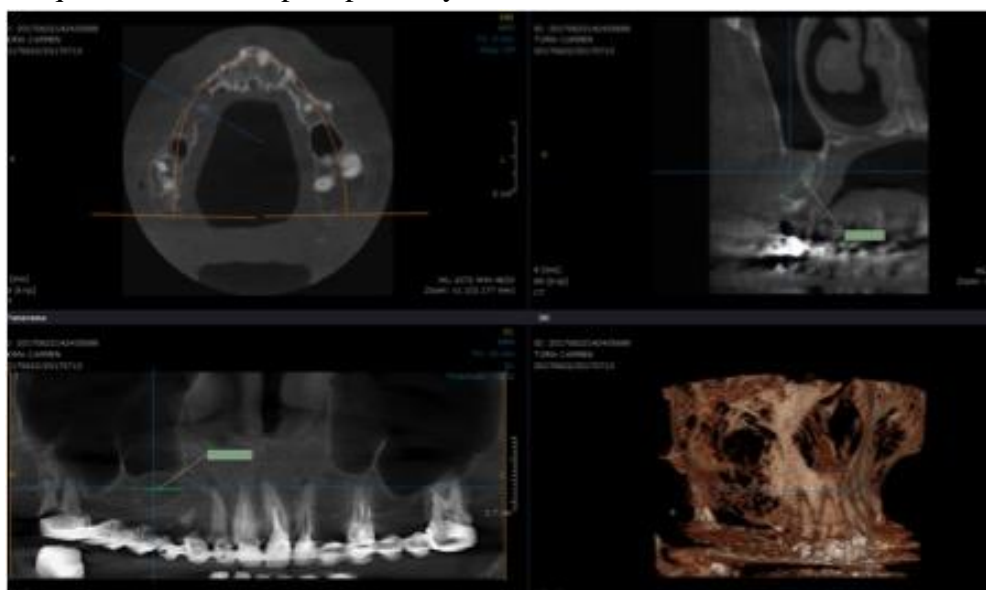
CBCT image before treatment: the presence of periapical cyst and bone resorption can be observed.
